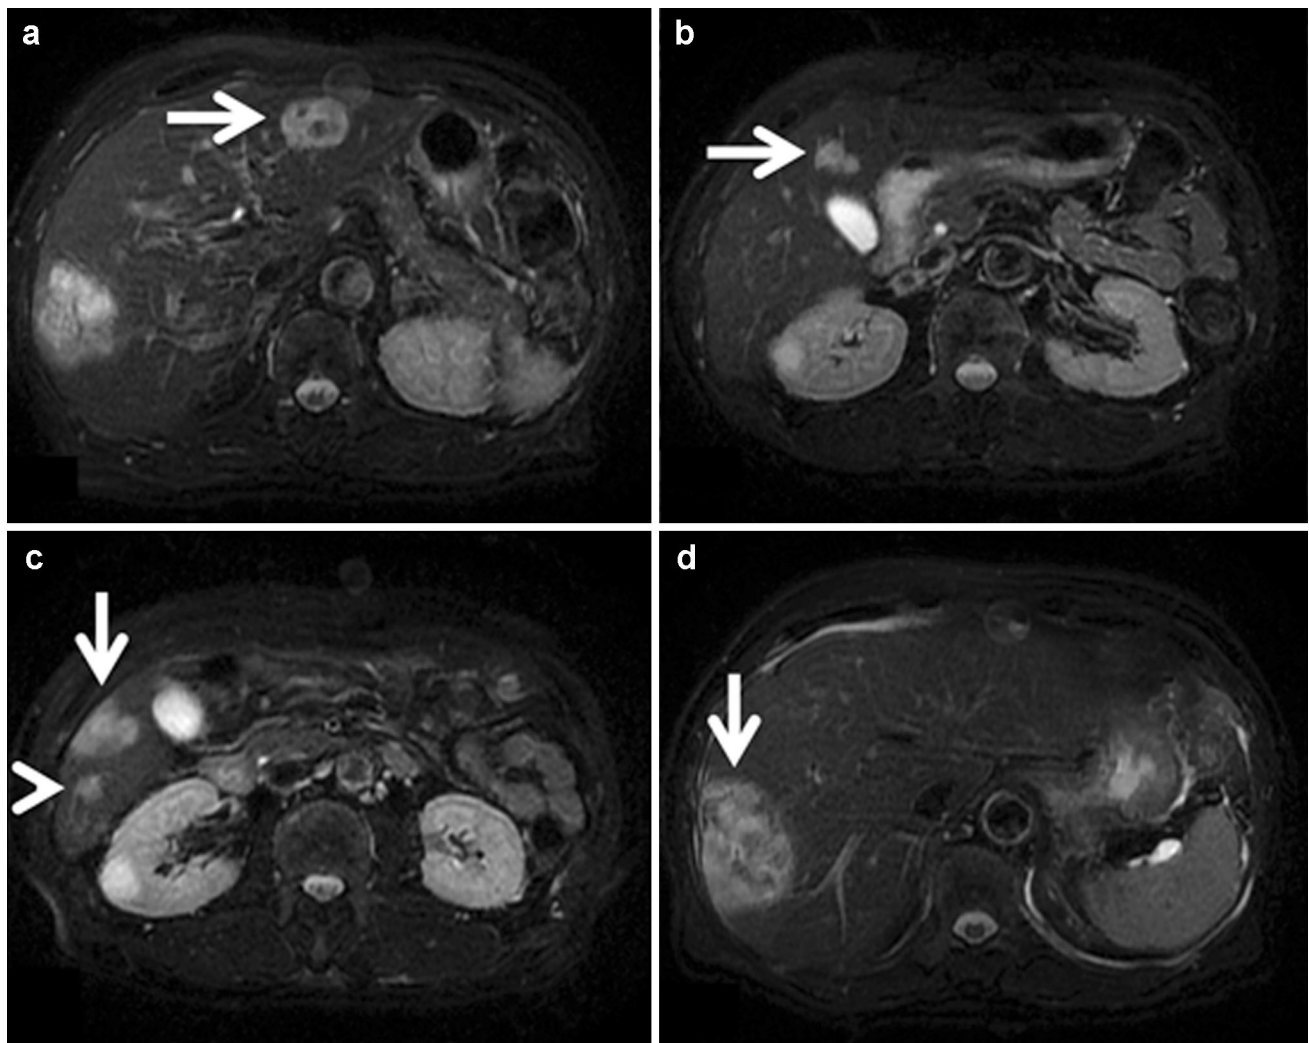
Magnetic resonance imaging revealed high intensity tumors in segment 3 (a; arrow), 4 (b; arrow), 5 (c; arrow), 6 (c; arrowhead), and 7/8 (d; arrow) of the liver on T2-weighted images
